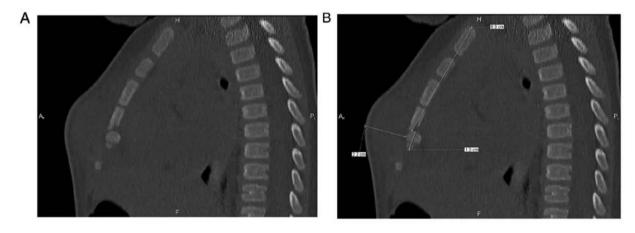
Preoperative CT findings in case B. (A) Multiplanar reconstruction image reveals lytic destruction of the 4-5th sternebra and the boundary of the skin and pulp was not clear. Soft-tissue swelling of the anterior chest wall was particularly evident and it was bulging forward, suggestive of osteomyelitis of the sternum. (B) CT measurements: The distance between the suprasternal fossa and the site of dislocation was \sim 6.3 cm; the thickness of the sternal lesion was \sim 1.0 cm; and the depth of the skin incision to the sternal lesion was \sim 2.2 cm. A, anterior; H, head; P, posterior.
